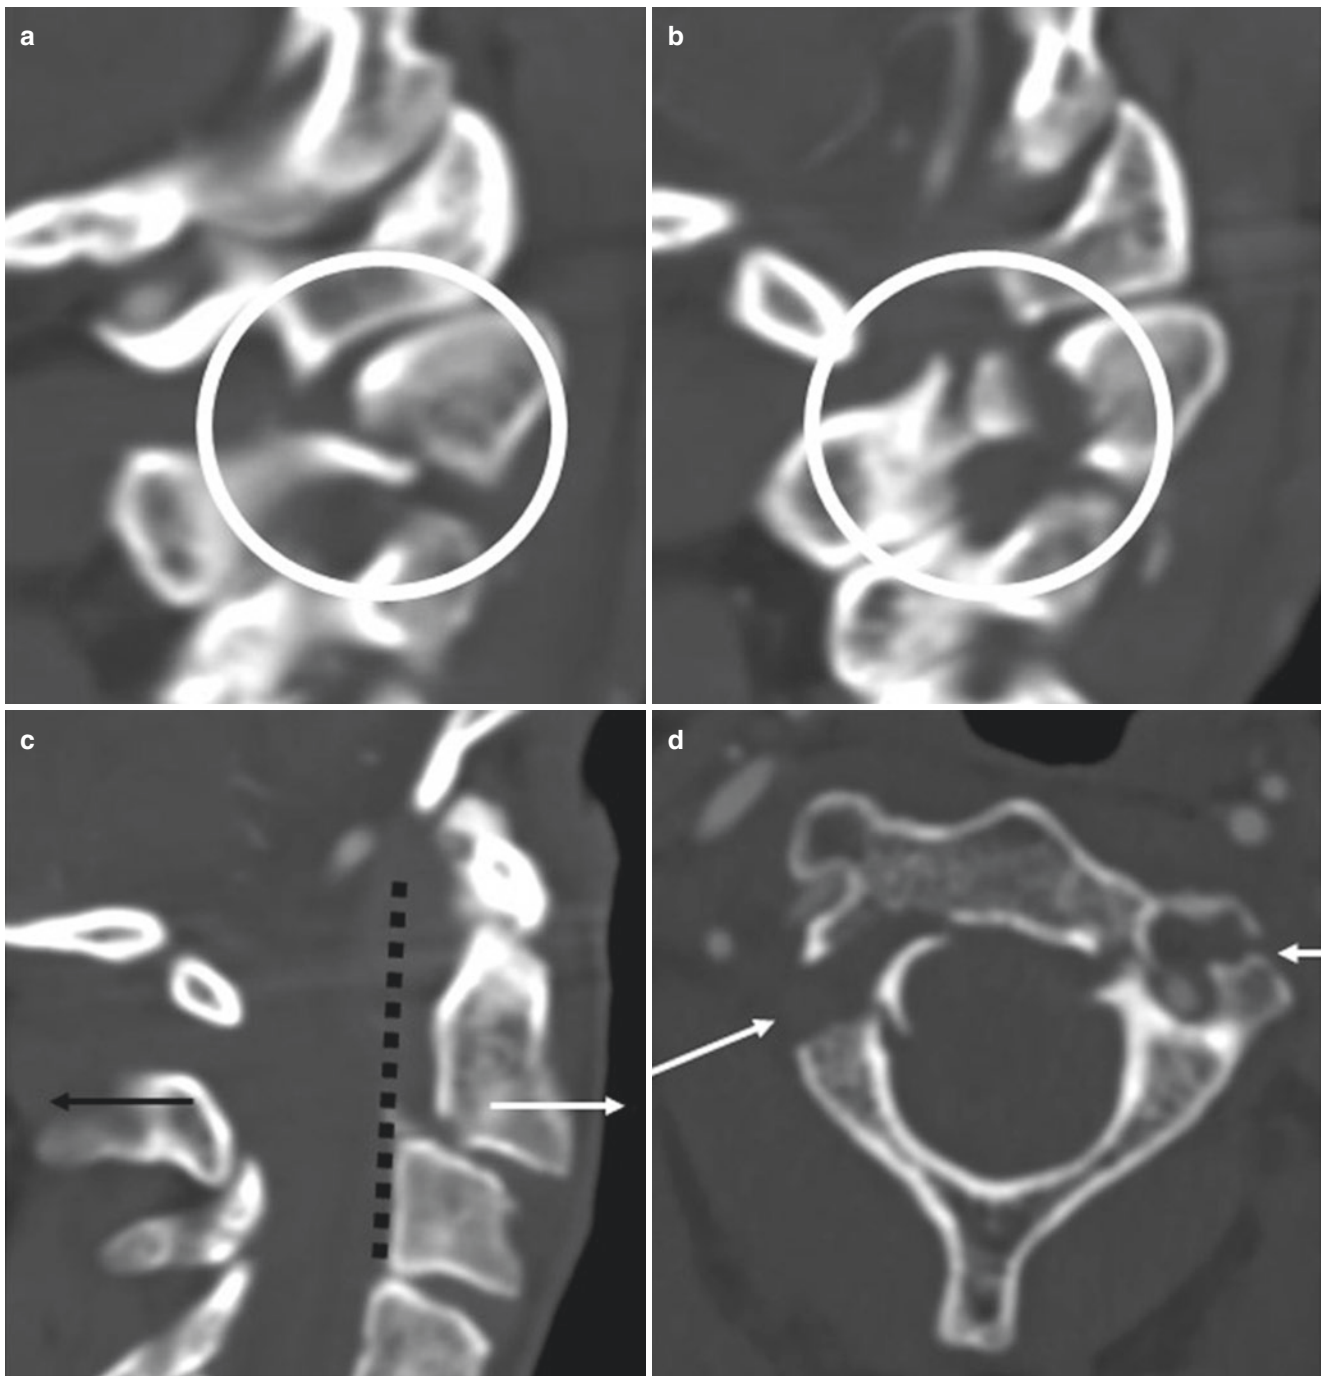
A 62-year-old woman with multiple sclerosis who presents status post fall. (a, b) Sagittal CT images of the cervical spine demonstrate bilateral C2 pars interarticularis fractures. (c) Sagittal CT image of the cervical spine demonstrates anterolisthesis (white arrow) and posterior displacement of the C2 posterior elements (black arrow). (d)
